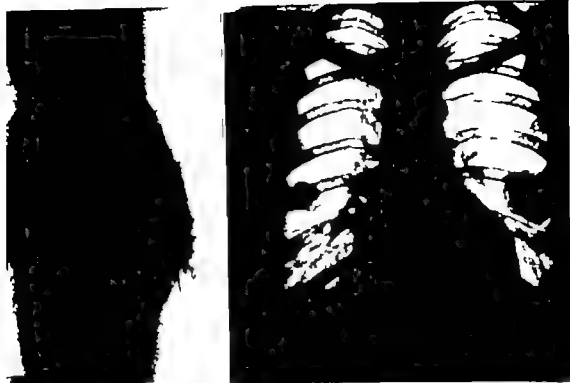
Roentgenograms of a patient who lived four years following amputation for osteogenic sarcoma of the femur in spite of chest metastasis. The leg was amputated on February 14, 1940. Metastasis to the left chest appeared in March, 1941. The patient died in March, 1944. He was bedridden in April, 1941 but regained his health and stayed apparently well for more than 2 years on dicalcium phosphate with viosterol and stilbesterol, 2% mg. daily.
